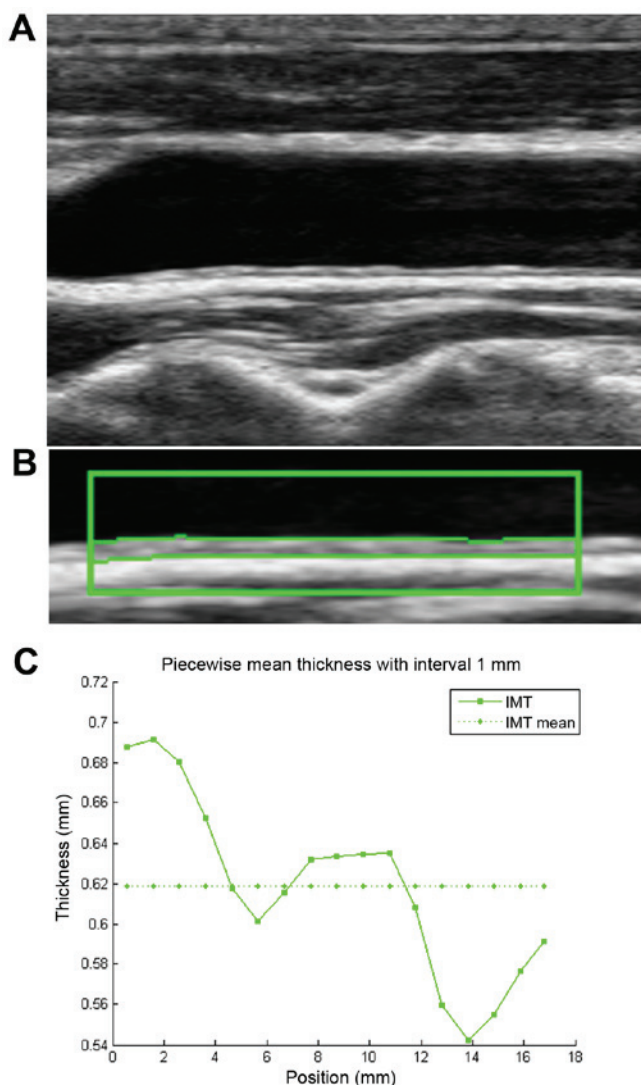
Carotid IMT and intima-media roughness measurements. (A) Ultrasound image of carotid longitudinal axis (depth 2.5 cm) (B) On ultrasound images, the carotid intima-media boundary is delineated by software. (C) Curve of IMT in the region of interest. IMT, intima-media thickness.
